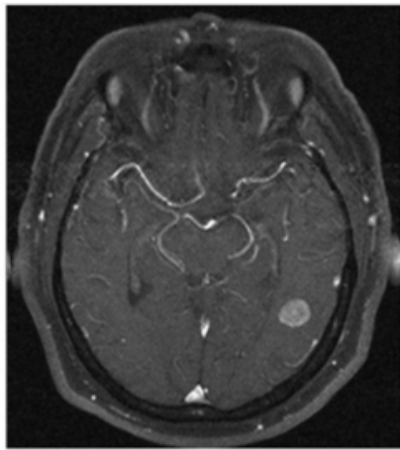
Axial T1 with Gadolinium MRI showing left temporal lesion
